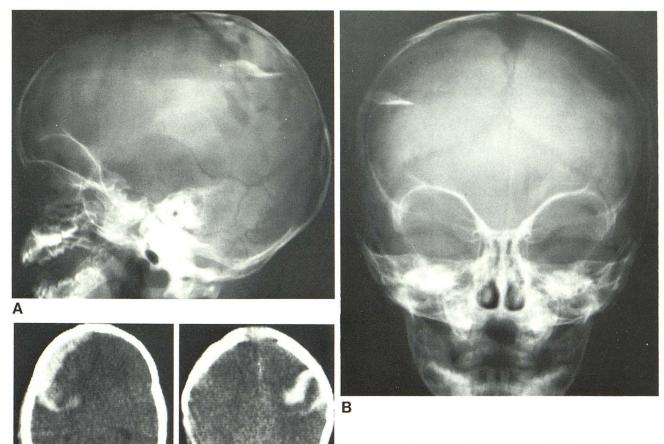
Case 1. A and B, Linear right parietal fracture. Multiple depressed fractures in right parietal bone and single depressed fracture in left occipital bone. Many bony defects are circular; some are elongated and parallel. C and D, CT scans after onset of disseminated intravascular coagulation. C, Small right intracerebral hematoma extends into much larger frontoparietal subdural hematoma. D, Left intracerebral hematoma extends to cortical surface.
